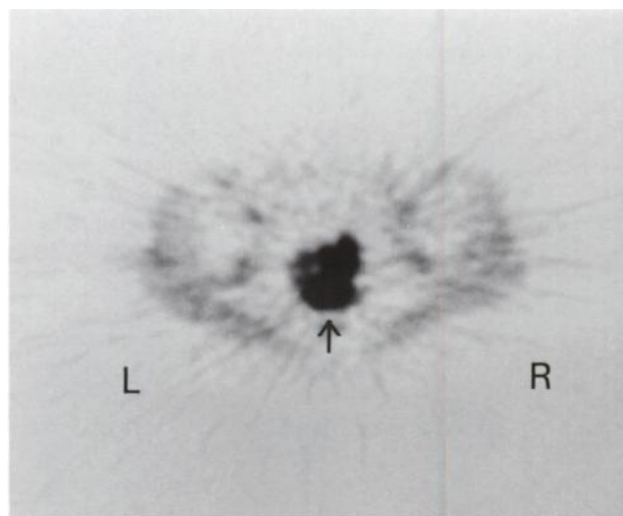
Carbon-11-methionine PET image of a patient with cervical squamocellular carcinoma that caused hydronephrosis (Stage IIIB, arrow; Patient 6, Tables 1 and 2). The SUV of the tumor is 11.2, and the K_i value is 0.28.
